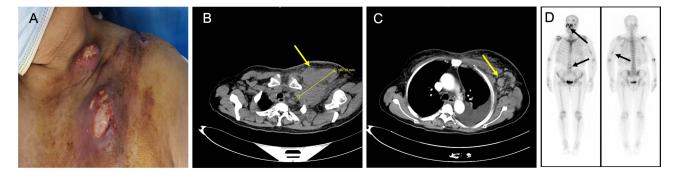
Figure I Clinical manifestations, imaging findings. (A) Several erythematous swellings, ranging from egg-sized to fist-sized, were seen on the skin of the left neck and upper chest. Some swellings were ulcerated, with visible secretions and oozing. (B) CT scan of the chest revealed an irregular soft-tissue mass (diameter is about 107.53 mm) in the left anterior upper chest wall (yellow arrow). (C) Multiple enlarged lymph nodes in the left axilla (yellow arrow). (D) ECT showed small patches of abnormally dense shadows (black arrows).
